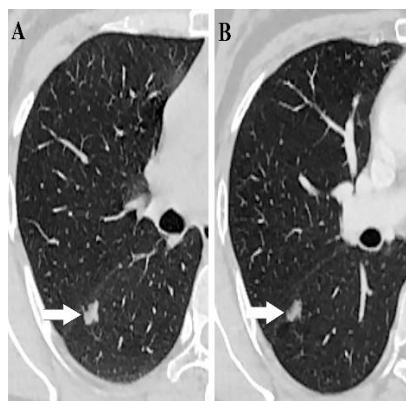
Axial CT images lung window showing A, a 12 mm solid lung nodule (arrow) at baseline CT (Lung-RADS 4A nodule) that demonstrates a 2 mm reduction in size at B, >3-month follow-up CT. This nodule would be reclassified as a Lung-RADS 3 nodule in Lung-RADS 2.0.
